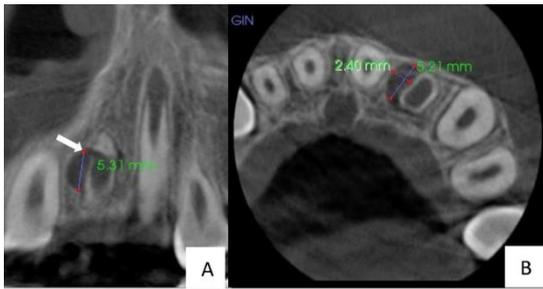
24-month recall CBCT of the patient
